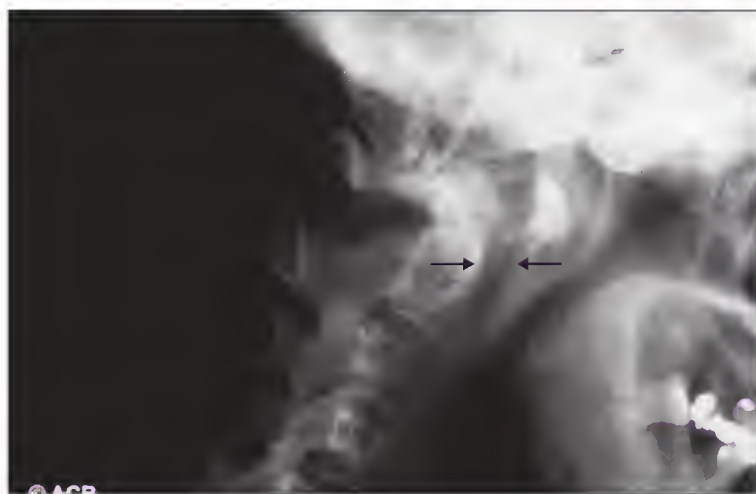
This radiograph of a rheumatoid cervical spine in flexion demonstrates atlantoaxial subluxation as the arch of C1 slides forward (arrows). (From *Clinical Slide Collection on the Rheumatic Diseases*, American College of Rheumatology.)
